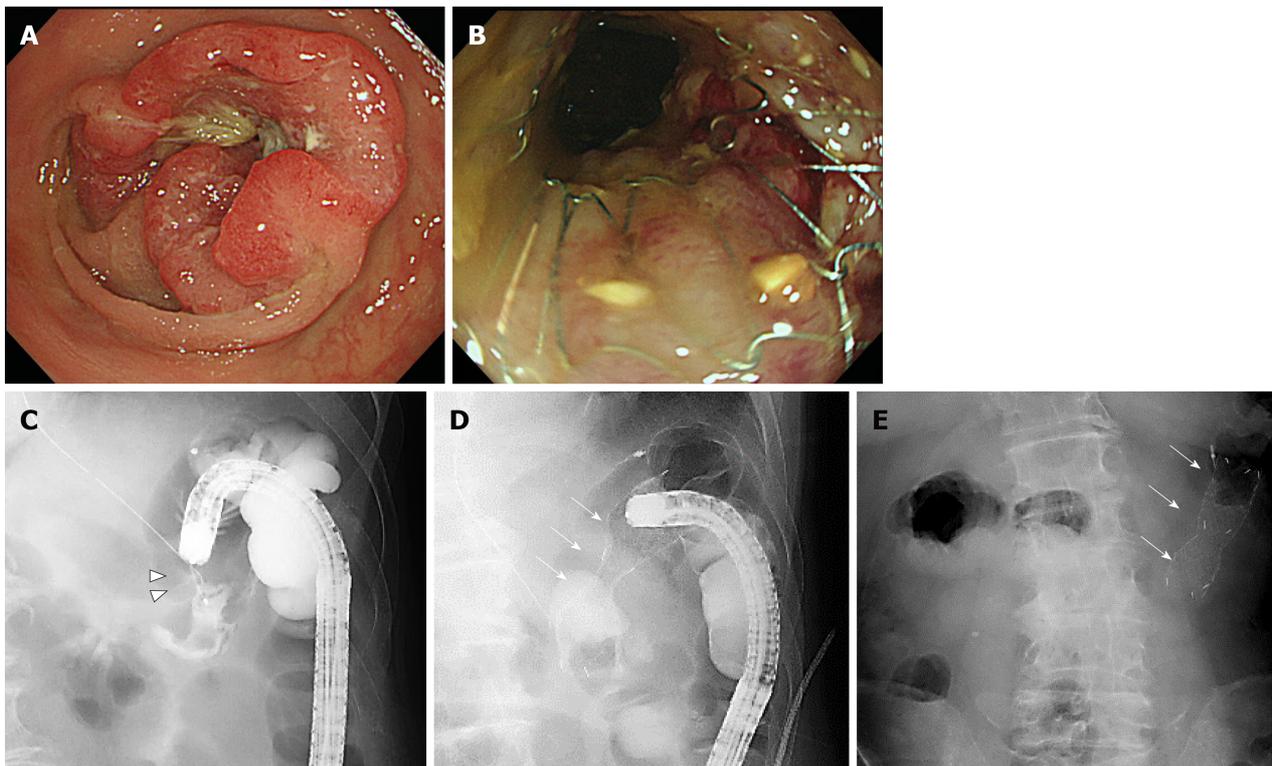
One of the bridge-to-surgery cases using the newly developed Niti-S MD type stent. A and C: The patient was an 83-year-old man with peritoneal type 2 advanced colorectal cancer (arrowhead) in the transverse colon; B and D: Using a smaller caliber colonoscope, we placed a 22 mm × 8 cm stent (arrow); E: Abdominal radiograph 2 d later shows firmly expanded stent successfully decompressing the acute obstruction. Tight stenosis is seen, and the enhanced expansible force of this stent enables successful decompression.
